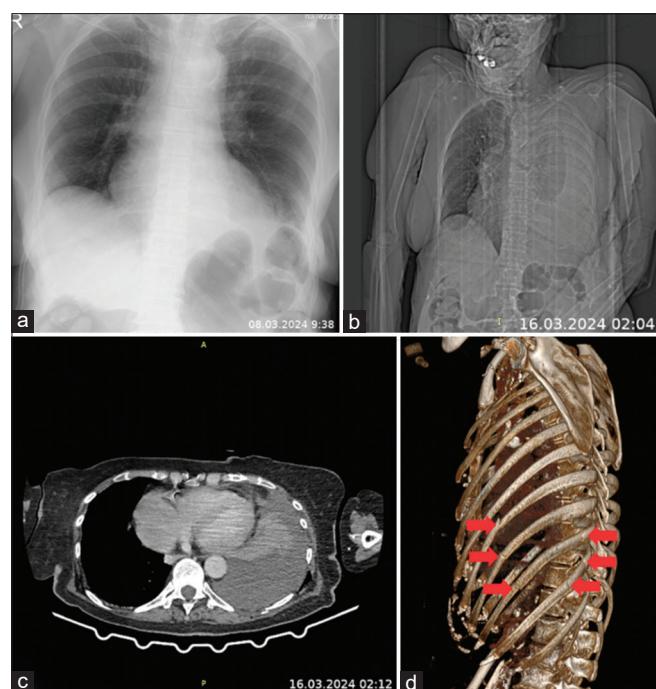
(a) Anteroposterior chest X-ray on the day of the patient's fall, showing fractures of the 7th and 8th ribs on the left side. (b) Axial chest computed tomography (CT) demonstrating a large left-sided hemothorax with near-complete lung collapse and mild rightward mediastinal shift. (c) Axial CT showing fluid in the left pleural cavity, causing near-complete left lung collapse. (d) Three-dimensional CT projection depicting ribs fractures from 7th to 10th on the left side. Fracture sites are marked by red arrows
